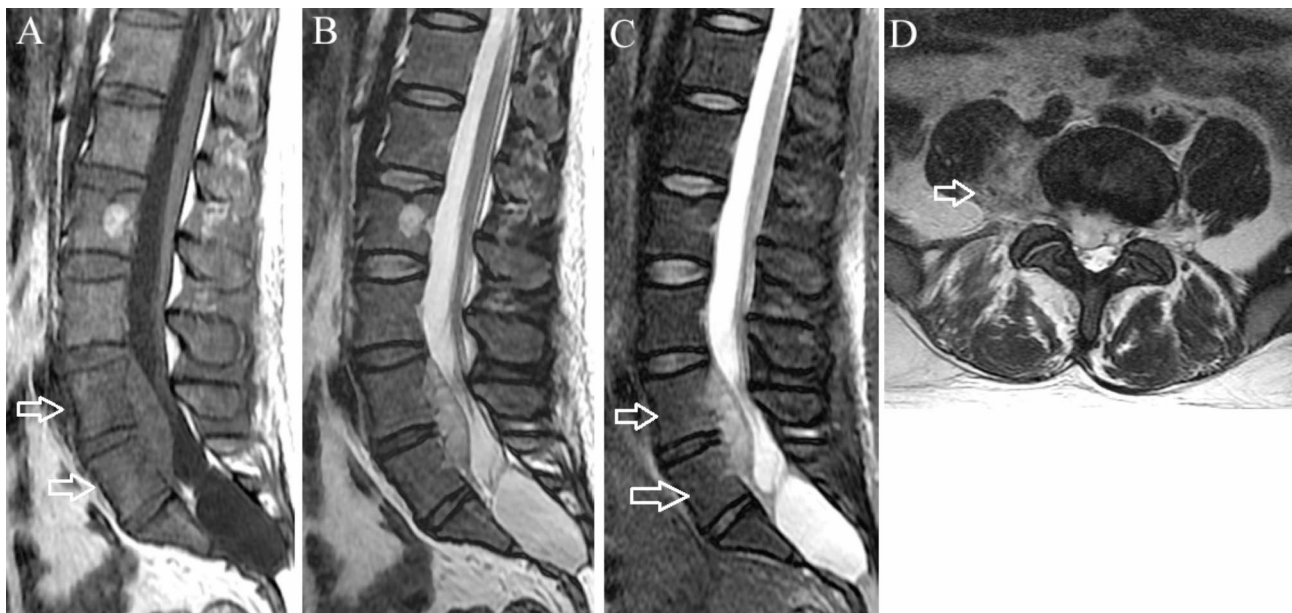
Phlegmonous stage primary L4-5 spinal epidural abscess in a 37-year-old man. (A) Sagittal T1-weighted imaging shows a fusiform homogeneously isointense lesion ventral to the thecal sac at L4-5. Edema is present in the L4 and L5 vertebral bodies (arrows). (B) On sagittal T2-weighted imaging, the lesion appears homogeneously hyperintense. (C) On sagittal short tau inversion recovery imaging, the vertebral body edema appears mildly hyperintense (arrows). (D) Axial T2-weighted imaging demonstrates the lesion extending through the neural foramina on the right into the paraspinal region (arrow)
